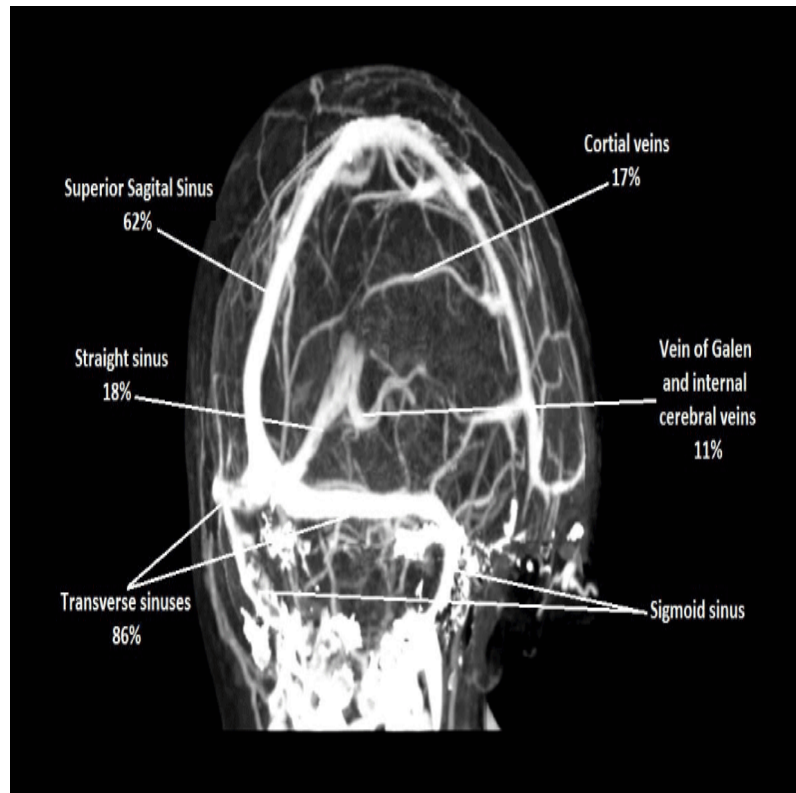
CT Venography demonstrating the sinuses involved in CVT
